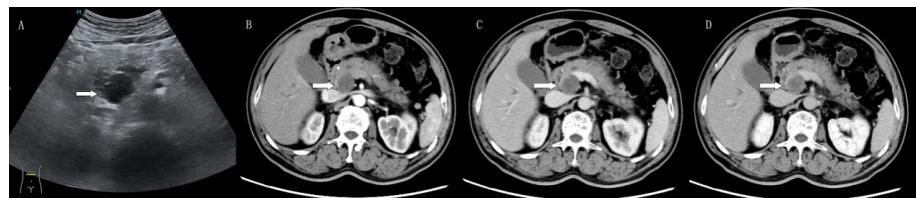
(A): Ultrasound Imaging indicates a 36 mm × 27 mm hypoechoic mass. (B): CT Arterial Phase Imaging. (C): CT Venous Phase Imaging. (D): CT Delayed Phase Imaging. B, C, D three-phase CT scans reveal a hypodense lesion in the head of the pancreas
